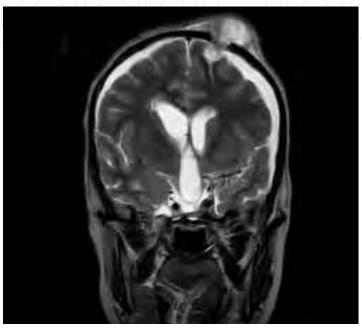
Coronal T2W MRI sequence showing bilateral subdural hygromas and subcutaneous collection post endoscopic 3rd ventriculostomy for hydrocephalus. The stoma later blocked and a shunt was placed.
